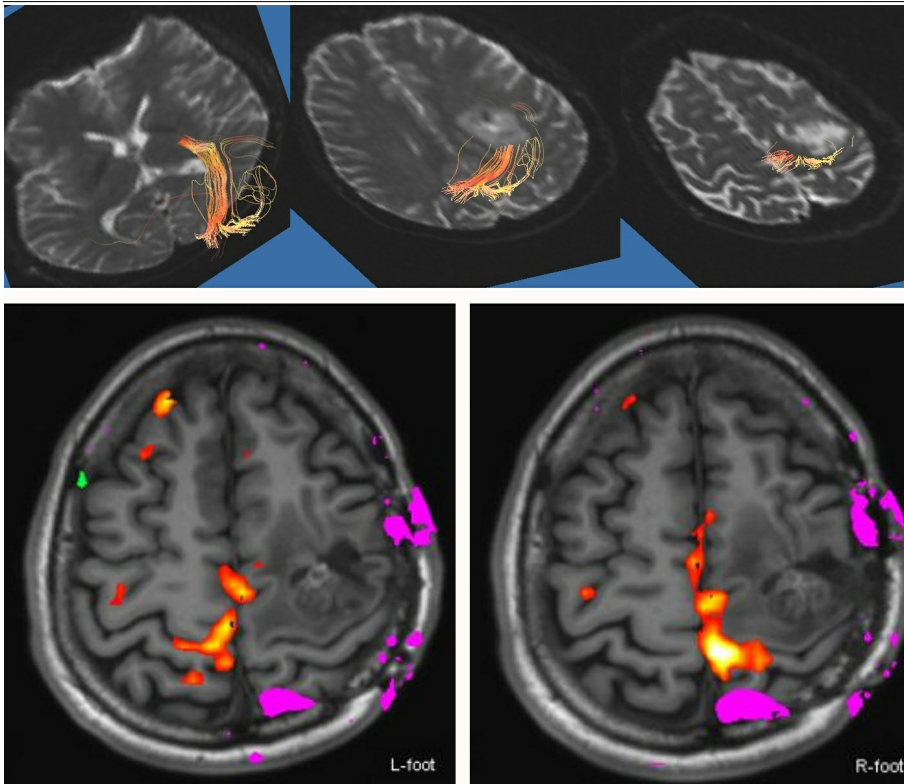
MRI before second operation. Tractography which was calculated by volume one showing corticospinal tract located at parietal side of the lesion (upper). Functional MRI by moving foot joint showing that hot spot of lower left and lower right looks almost as a mirror image.
